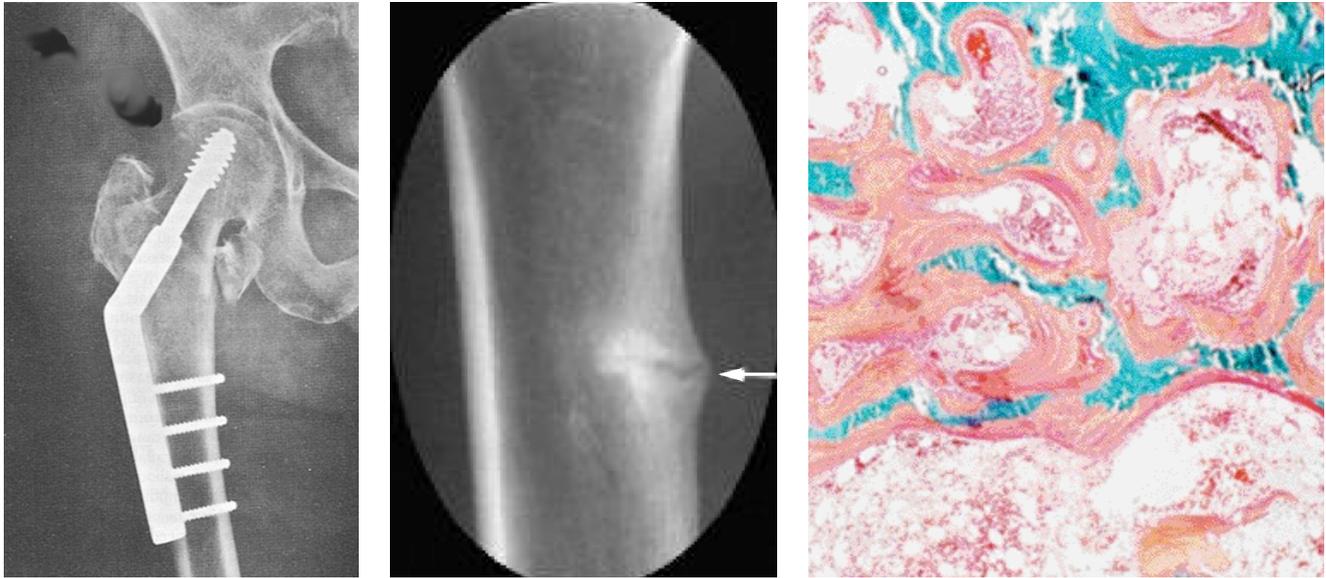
Examples of fragility fractures occurring in patients with vitamin D deficiency. a (left). X-ray of osteoporotic hip fracture treated by surgical stabilisation. b (centre). X-ray of pseudofracture of femoral shaft (also known as Looser zone). c (right) Bone biopsy of classic osteomalacia showing decreased bone volume (blue) and increased osteoid or unmineralised bone (orange).
